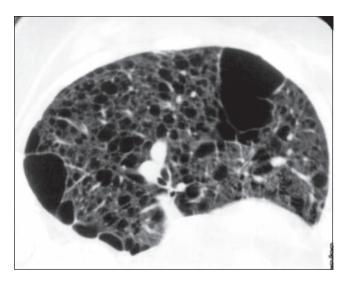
LAM. HRCT scan in a 44-year-old woman with LAM demonstrates multiple, thin-walled cystic radiolucencies bilaterally. Note the two large lesions, representing confluent cysts. From Lynch JP III, Raghu G. Major disease syndromes of unknown etiology. In: Baum G, Crapo J, Karlinsky J, et al, eds. Textbook of pulmonary diseases. 7th ed. Philadelphia, PA: Lippincott Williams & Wilkins, 2004; 629–655.
